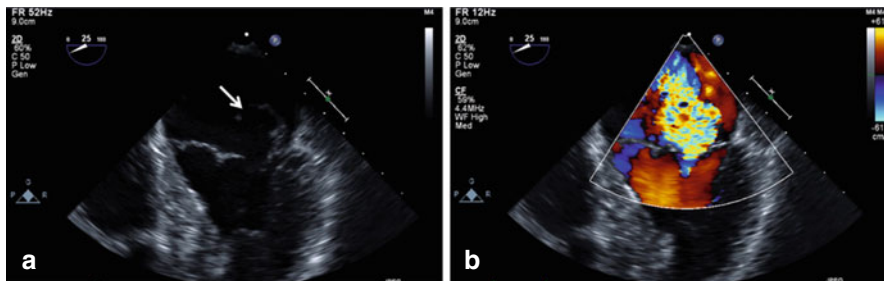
(a, b) Echocardiogram of a flail leaflet of the mitral valve resulting in severe mitral regurgitation. (a) Posterior leaflet displaced into the *left* atrium during systole. (b) Color Doppler showing severe mitral regurgitation (MR)
